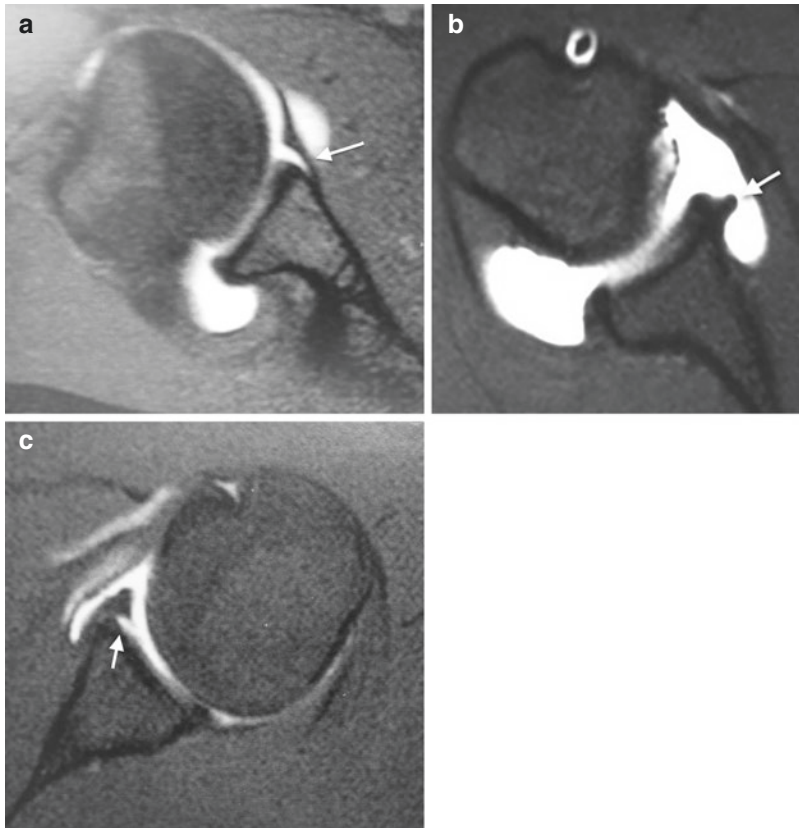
Arthro-MRI after anterior shoulder dislocations. (a) Anterior labrum periosteal sleeve avulsion (ALPSA) lesion; (b) chronic ALPSA lesion; anterior
